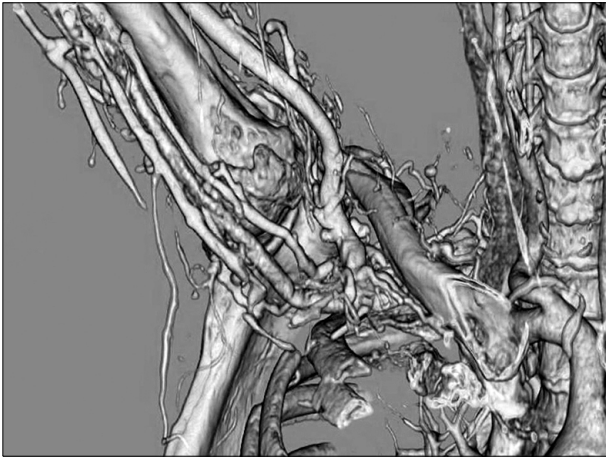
Chest computed tomography with 3-dimensional reconstruction shows venous engorgement due to compression of fractured 1st rib and clavicle.
